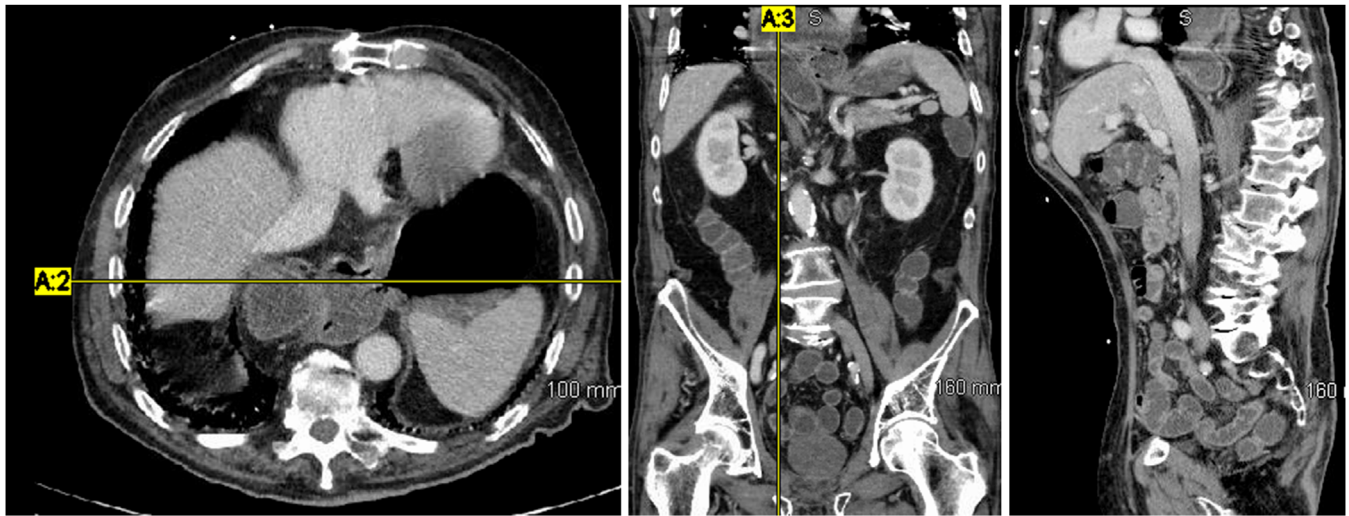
Axial and coronal views on contrast-enhanced abdominal computed tomography (CT). Contrast-enhanced CT shows fluid-filled dilated gastric antrum and duodenum extending into the intrathoracic cavity. There is twisting of the stomach along the longitudinal line parallel to the gastrohepatic omentum
